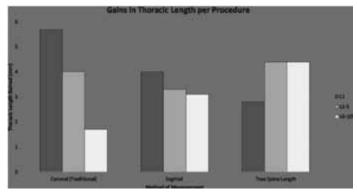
Thoracic length gains per lengthening procedure as measured traditionally (appearance of diminishing returns), with sagittal radiographs, and with true spine length.
